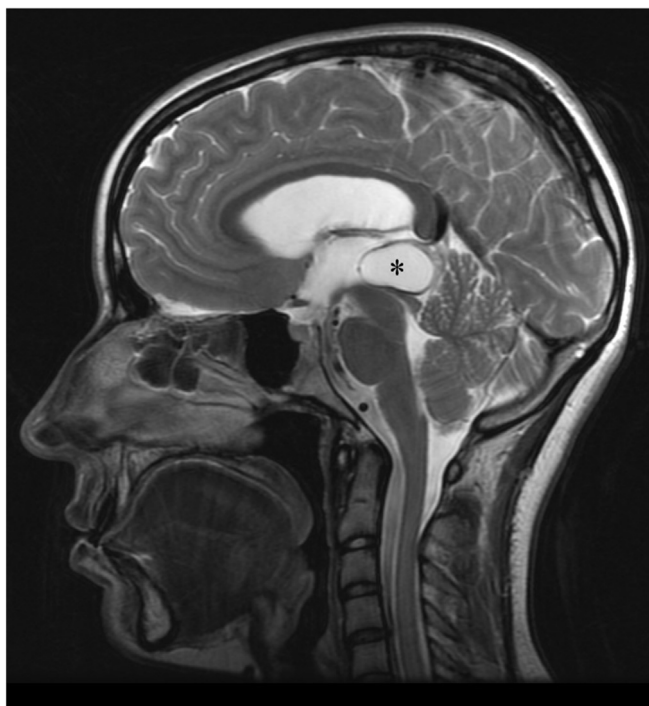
Sagittal magnetic resonance imaging of the human brain (T2 weighted image) showing a typical pineal cyst (asterisk).
